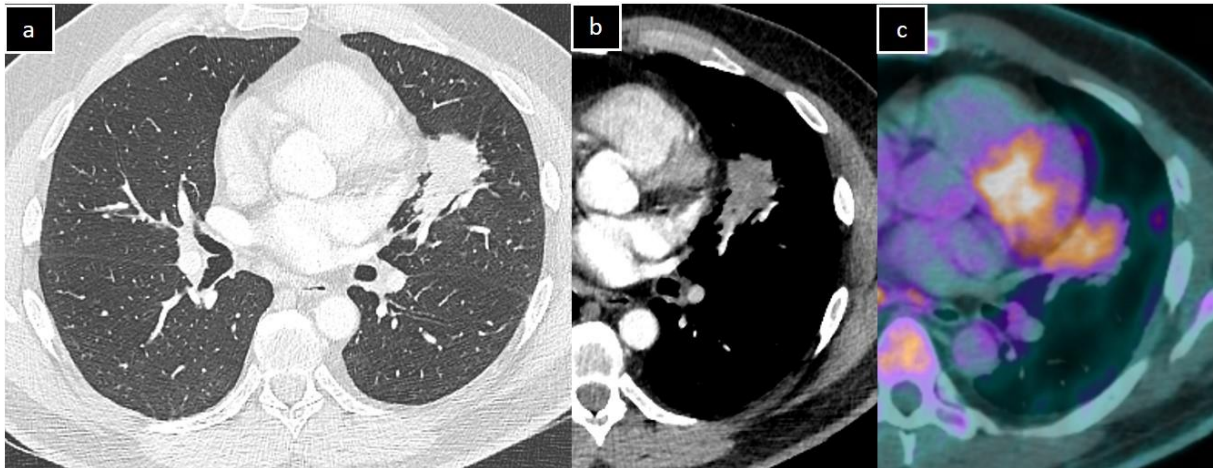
50 yo male with hyper IgM syndrome. Axial CT images in (a) parenchymal and (b) mediastinal windows show an ill-defined alveolar consolidation in the lingula, with moderate FDG uptake on TEP-CT (c). Bronchoalveolar lavage was normal and the lesion persisted despite 2 courses of antibiotics. Surgical resection provided a diagnosis of MALT lymphoma
